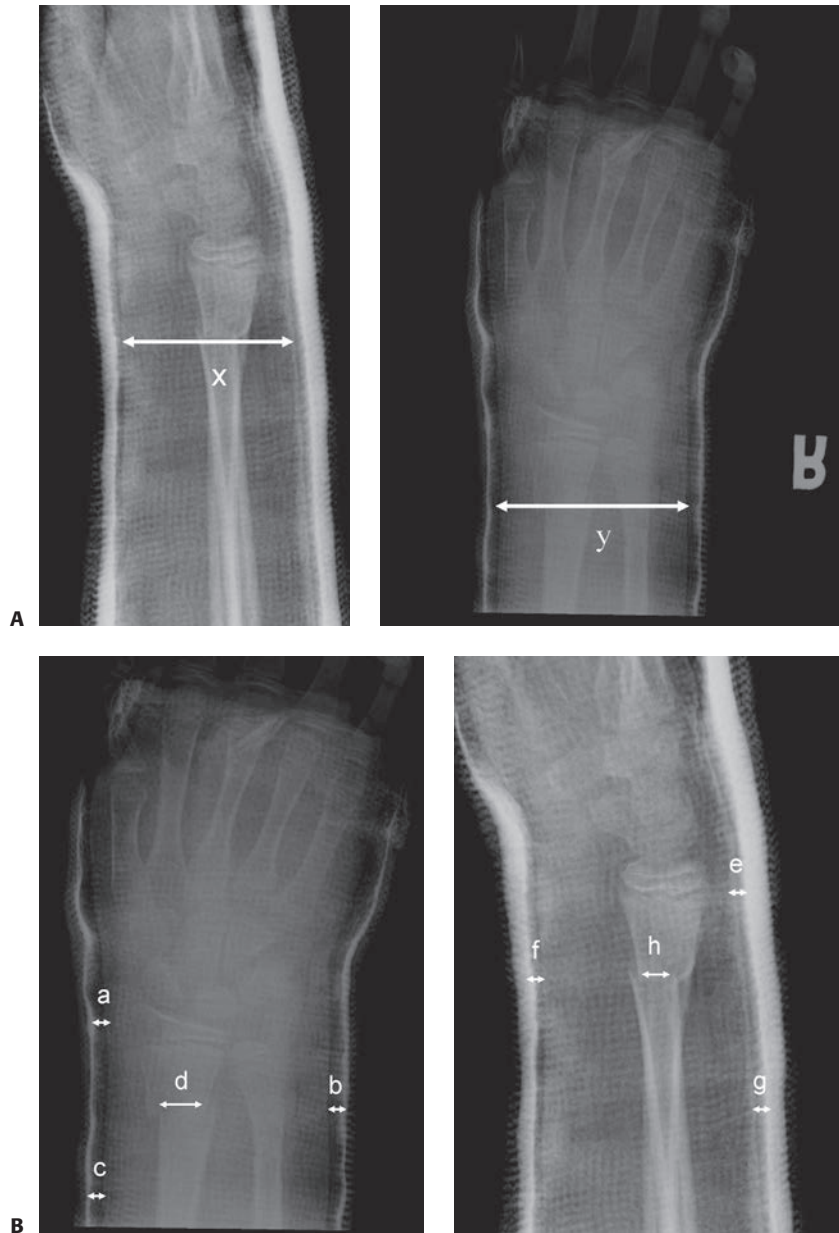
Radiographic evaluation of cast mold. A: Cast index (x/y) is the ratio of the inner cast diameter at the level of the fracture on the lateral projection (x) to the inner cast diameter at the level of the fracture as seen on the anteroposterior (AP) view (y). B: The three point index $[(a + b + c)/x] + [(d + e + f)/y]$ is the sum of the three critical gaps divided by the contact area of the fracture fragments as assess on both the AP and lateral views.
